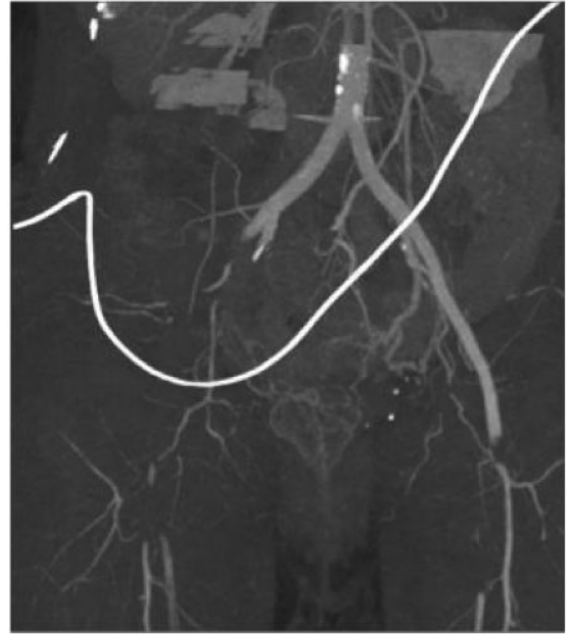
Computed tomography angiography coronal section showing embolic occlusion of external and internal iliac arteries on the right, and distal common femoral artery on the left just above the femoral bifurcation.
